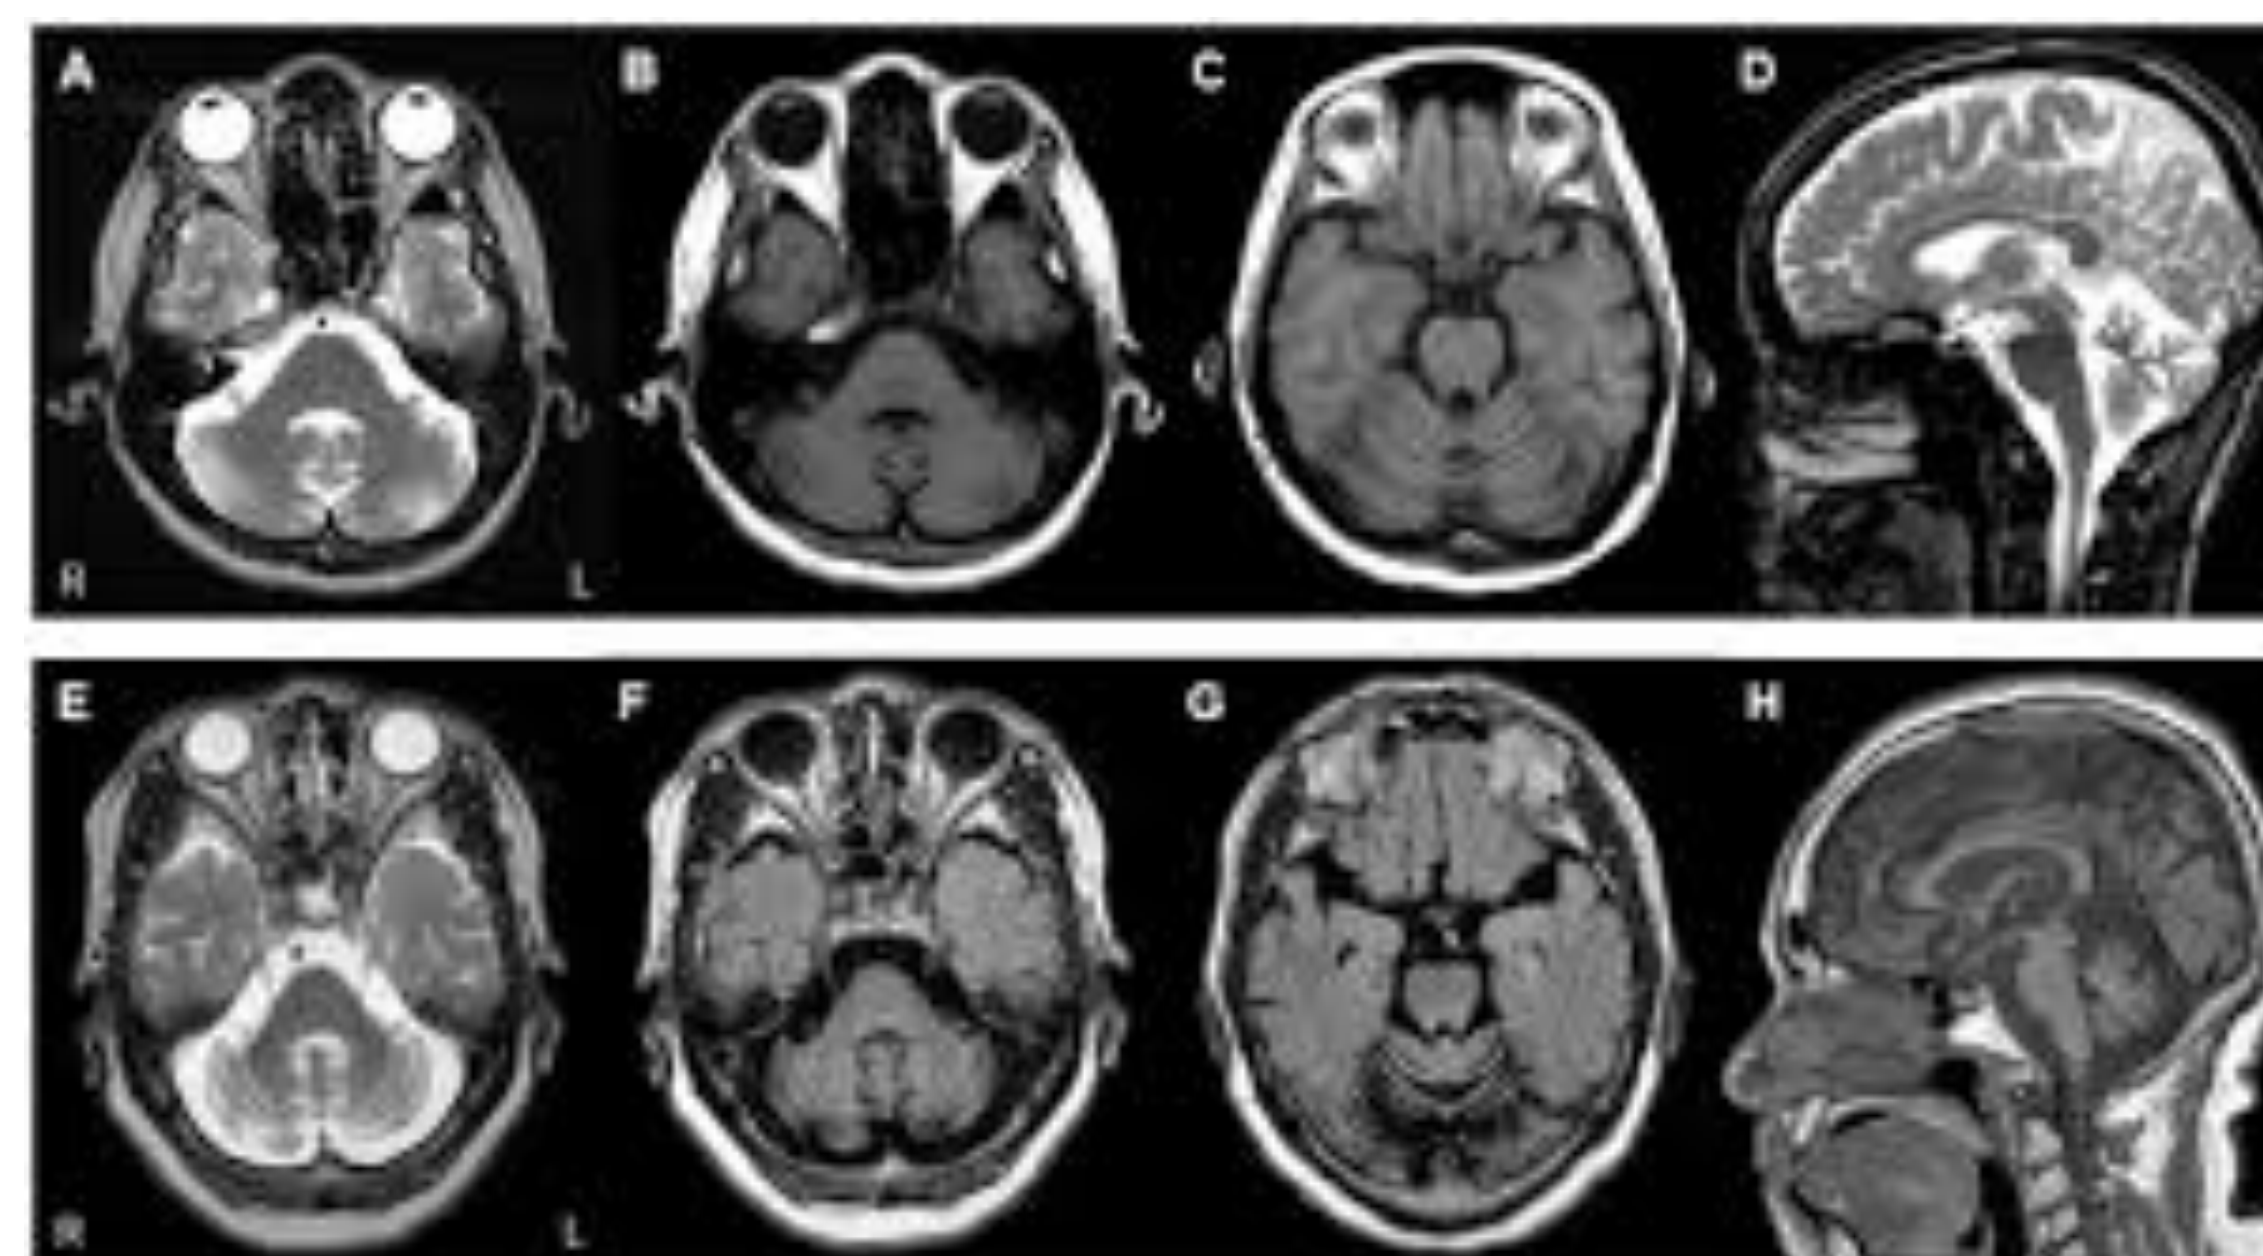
Brain MRI of patient #1 showing mild cerebellar atrophy
